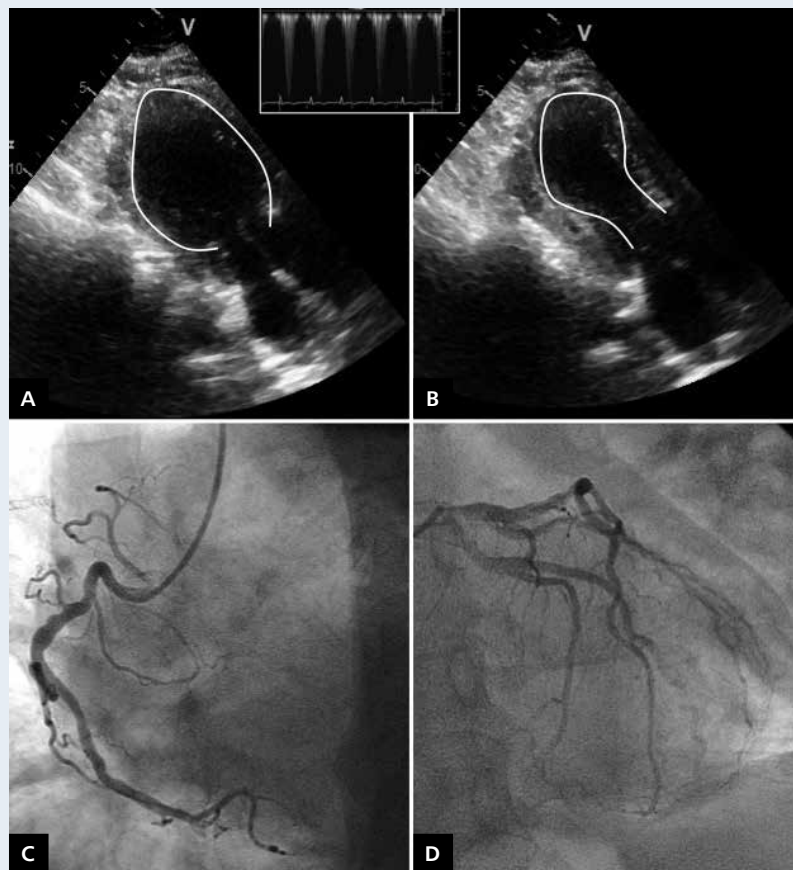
A, B. Bedside echocardiography; C, D. Coronary angiography
